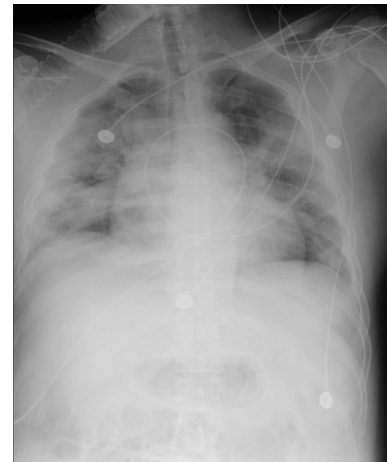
Posteroanterior Chest Radiograph, February 14,2020 (Illness Day 20, Hospital Day 17). The shadow of the heart was enlarged and full.
